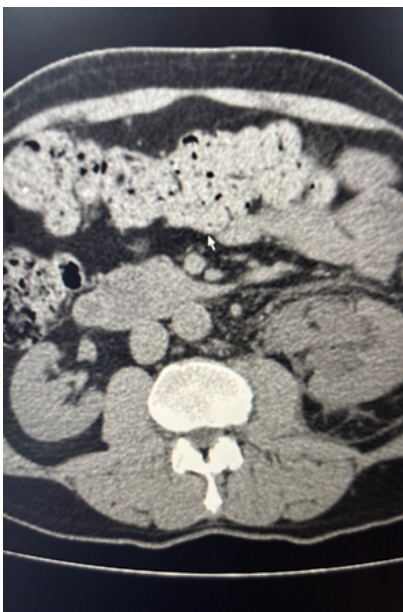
CT scan - in the left perinephric space, visible strands of oedema and fluid accumulating due to gravity, most likely urine.
